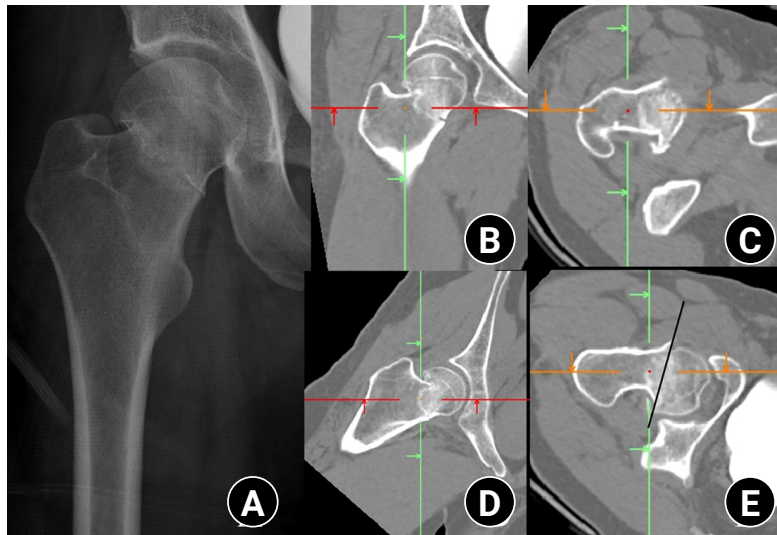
A 38-year-old male patient presented with hip pain following a 3 m fall. (A) The initial plain radiograph revealed a femoral neck fracture. (B, C) The computed tomography (CT) plane parallel to the femoral neck centerline identified a convex fracture with a Pauwels angle of 45.1° in the coronal plane. (D, E) Reorientation of the CT plane along the femoral neck demonstrated a cephalad-type fracture with an axial verticality of 75.8° in the axial plane.
